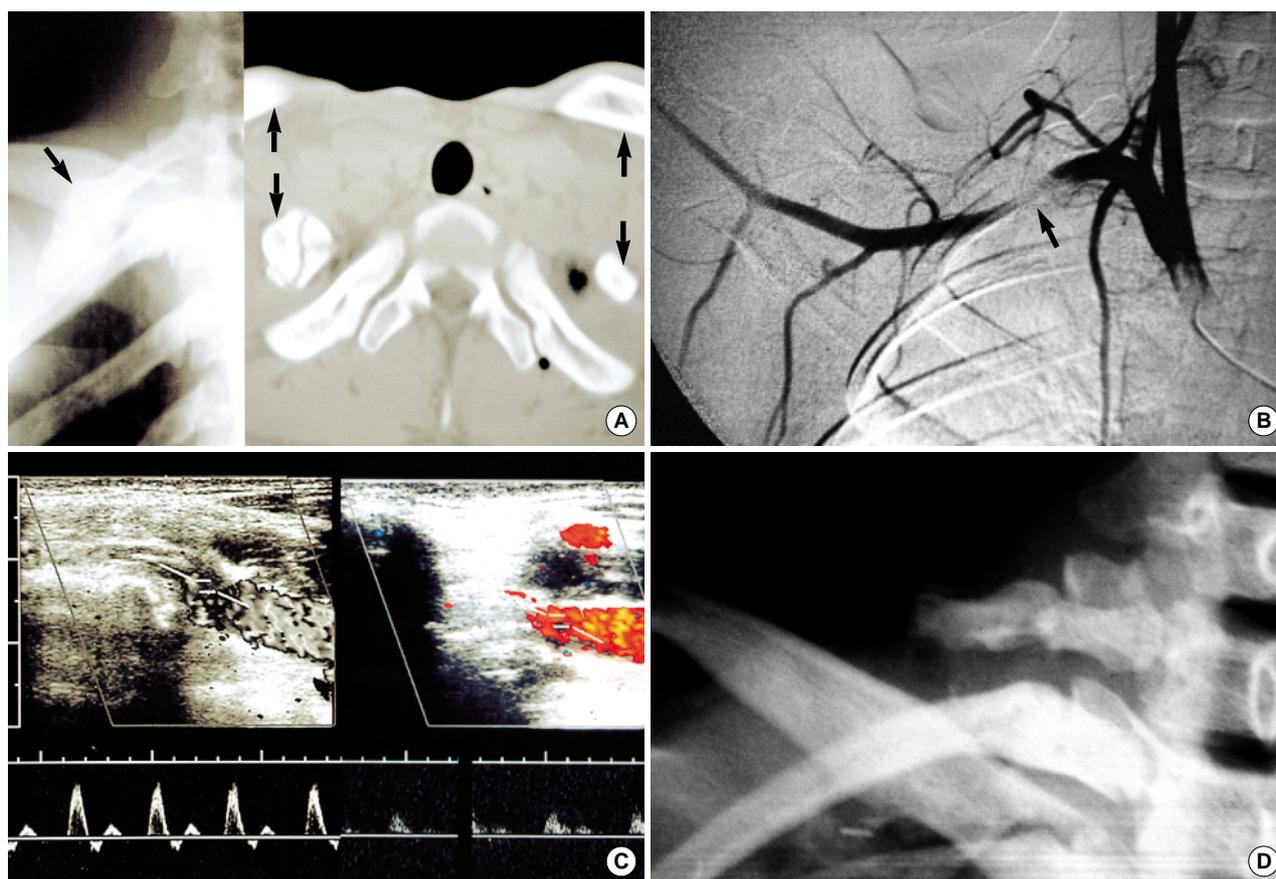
(A) The plain radiograph shows hypertrophied callus on the posterior aspect of the first rib (black arrow). The distance between clavicle and first rib was 5 mm shorter than that of left side on computed tomogram (difference of the distance between the two arrows). Nonunion was confirmed by this computed tomographic film on which gap was marked between two fragments. (B) At this position of hyperabduction, arterial pulse of right radial artery disappears rapidly. Dynamic arteriography depicted disruption of the axillary arterial flow by its narrowing at this position as well (arrow). (C) The Duplex ultrasonography, which has a function of a color Doppler, demonstrates the compression of the subclavian artery as at least a doubling of peak systolic velocity and reduction of the flow at hyperabduction over 90 degrees. (D) Postoperative plain radiograph after resection of the first rib including the hypertrophied callus.
